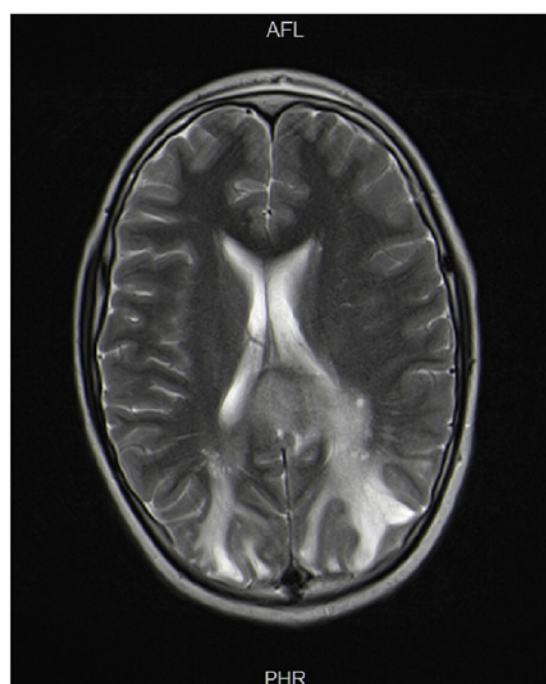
Magnetic resonance image (MRI) brain T2 weighted MRI image showing hyperintensity (oedema) of the parietal and occipital lobes bilaterally involving both white and grey matter. This is suggestive of posterior reversible encephalopathy syndrome (PRES). The mechanism of the vasogenic oedema seen is hyperperfusion due to a failure of auto-regulation which causes a disruption of the blood brain barrier. Other images (not shown), showed a lesion in the left superior parietal lobe which was hyperintense on the T1 weighted image (suggesting blood), with restricted diffusion on the diffusion weighted scans (suggestive of a recent infarct) and susceptibility artefact on the GRE scans (indicative of blood products). This finding were compatible with a recent haemorrhagic infarct. AFL
